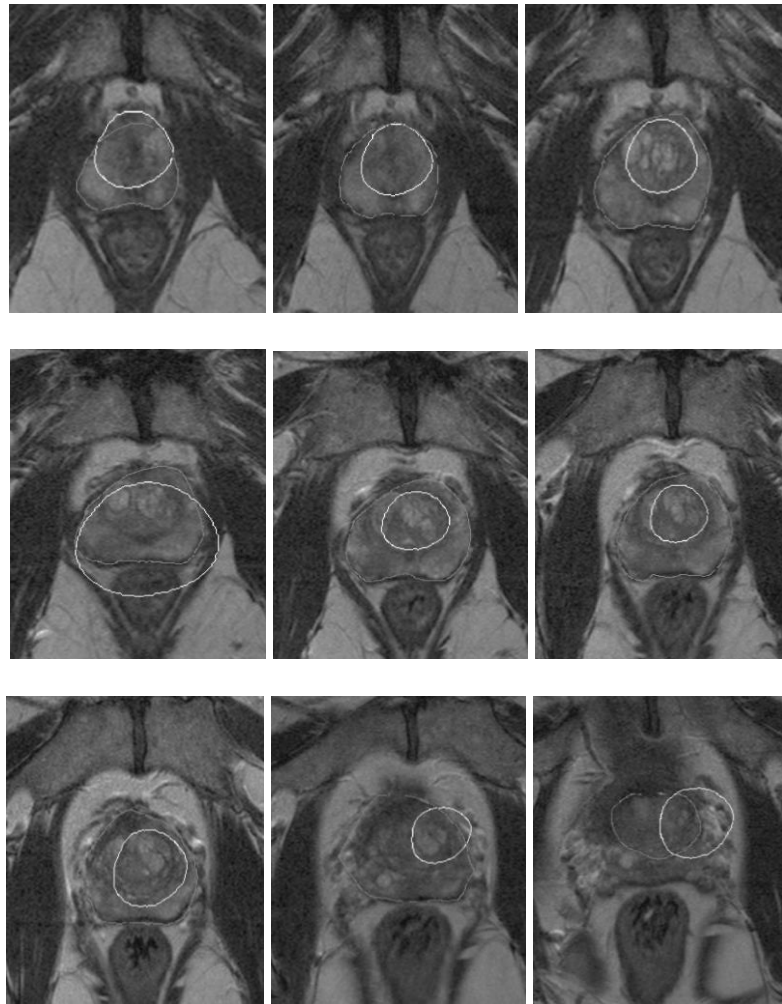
2D segmentation of an MRI image using the GA.
